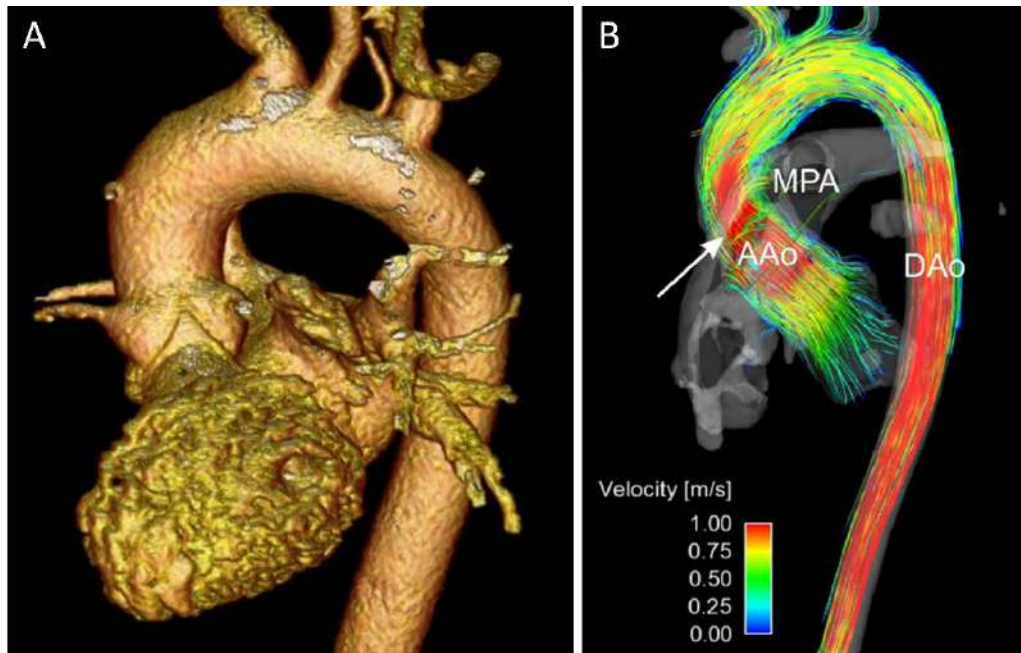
(A) Segmentation of an aorta from MRI imaging. (B) Flow through aorta analyzed with 4D-MRI.
